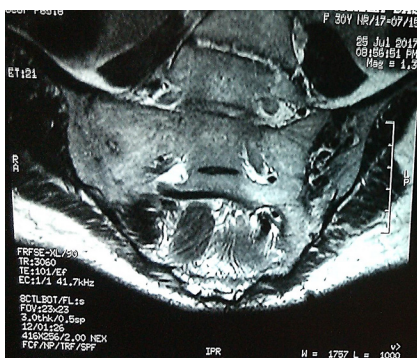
MRI scan of SI joints of the patient showing ankyloses of the right side and surrounding bone marrow edema, suggestive of active arthritis
